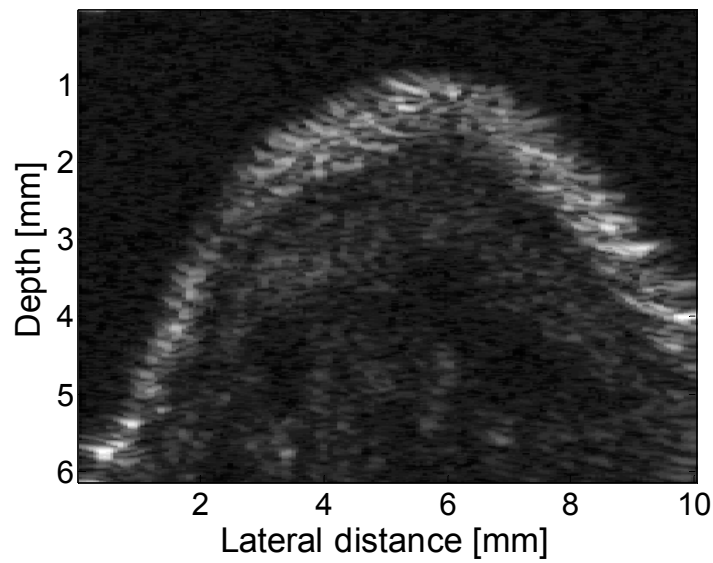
A high-frequency ultrasound image of a human finger acquired using our system. Penetration to depths greater than 5-mm is demonstrated.
